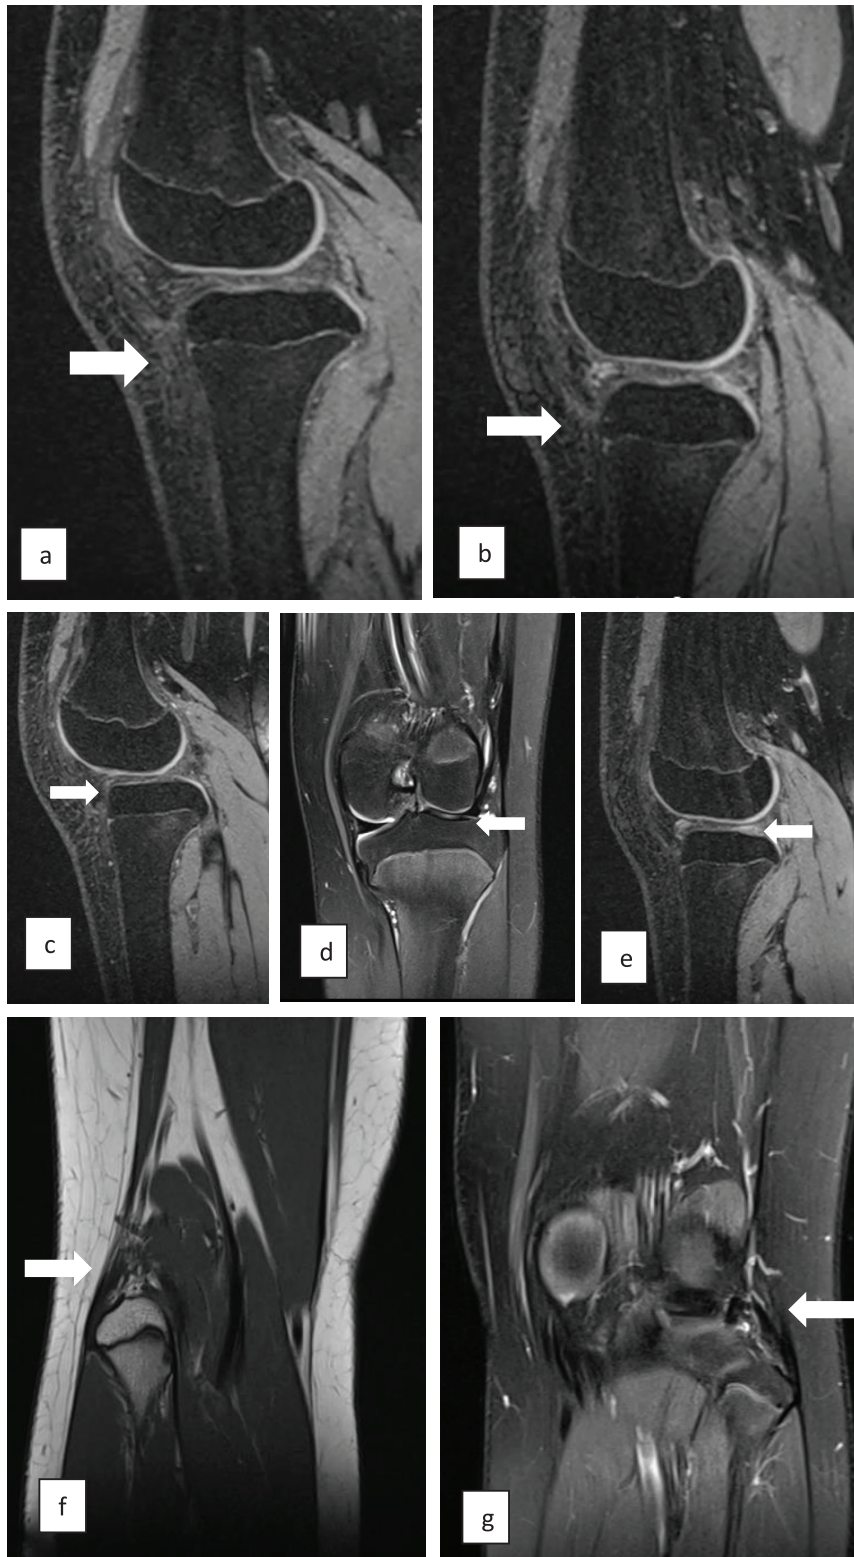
Sagittal view of T2-weighted MRI image of the right knee (a) and left knee (b) demonstrate total absence of patella. The quadriceps tendon is seen. Distally it continues as a thin fascia like structure that is inserted at the anterior knee. Patella tendon is not visualized, most likely hypoplastic (white arrow). (c) and (d) Thinning of the cartilage was observed at the lateral tibial plateau of the right knee at both sagittal and coronal view T2-weighted image of the right knee and sagittal view of the left knee (e) (white arrow). This may represent early degenerative changes of the knees. (f) Thickened lateral collateral ligament is visualized at its fibular insertion seen at coronal view of T1-weighted image of the right and coronal view T2-weighted image of the left knee (g) (white arrow). Intermediate signal intensity is also observed indicating chronic sprain that might contribute to the knee pain.
